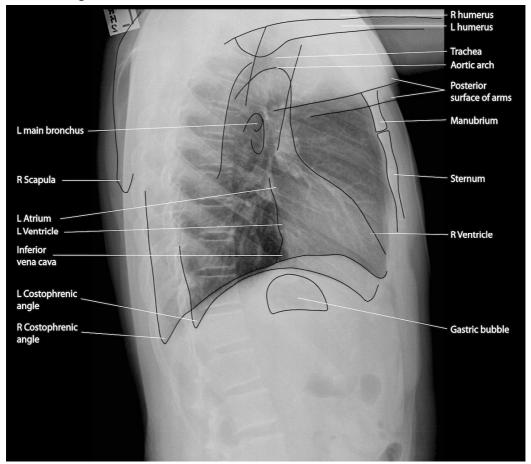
Plain radiograph of the thorax, lateral view.
